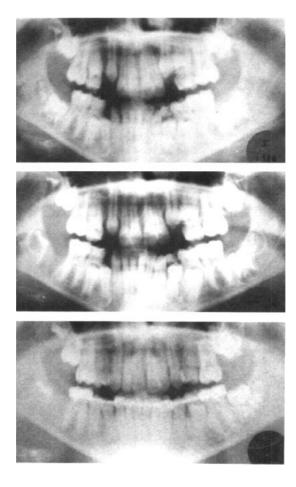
Surgical intervention to upright the unerupted third molar germ at the time of second molar extraction. Final radiograph one year later.
